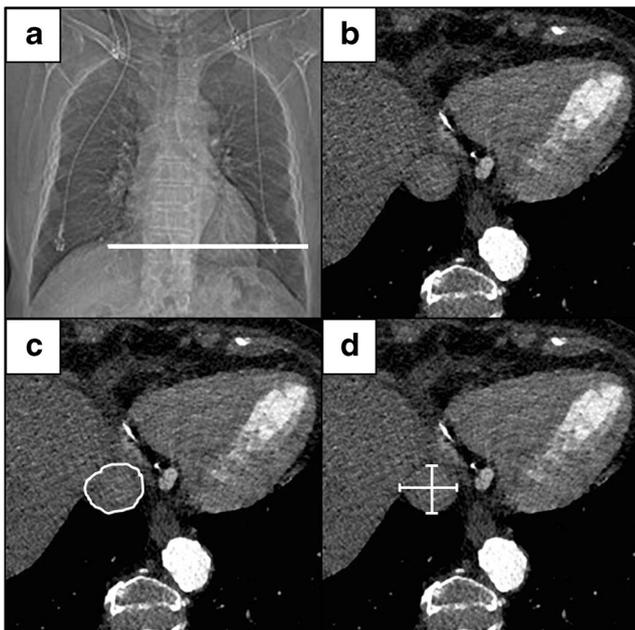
The suprahepatic IVC segment was evaluated just superior to the hepatic veins, below the junction with the right atrium (a) on axial CT slices (b). Area measurements (c) as well as measurements of short and long diameter (d) were performed
